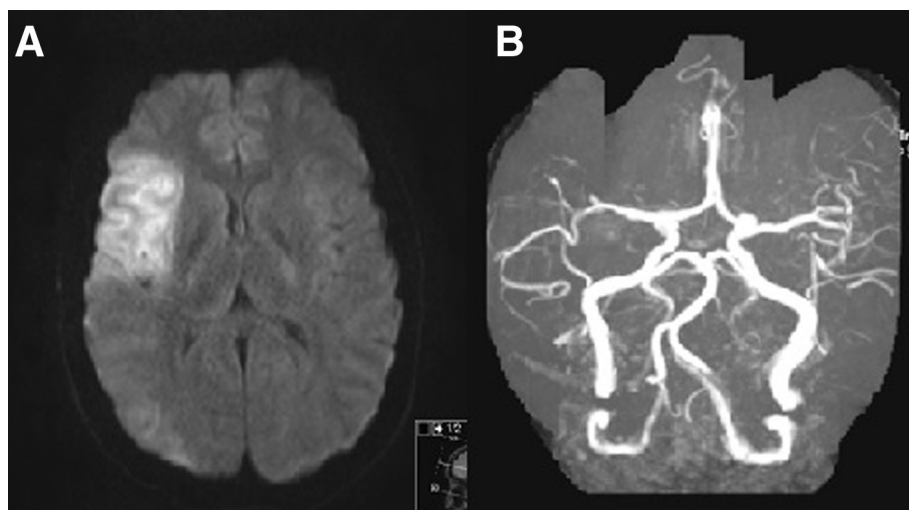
(A) DWI MRI brain showing acute right MCA infarct. (B) Intracranial MRA showing cutoff at the superior division of right MCA artery. Abbreviations: DWI, diffusion-weighted imaging; MRA, magnetic resonance angiography; MRI, magnetic resonance imaging.
